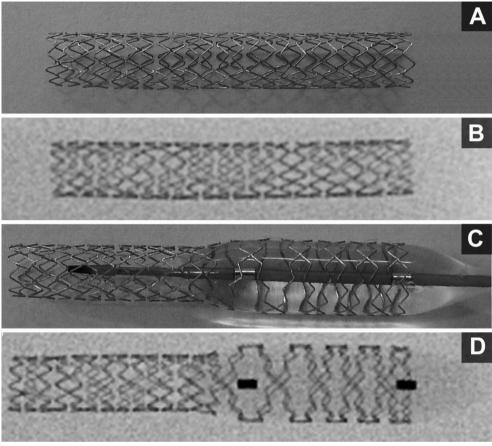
DES postdilatation (example of Endeavor Resolute stent): A) Photograph of DES after expansion at 14 atm; B) high resolution radiographic image of A; C) photograph of partial proximal postdilatation with 5 mm non-compliant balloon at 18 atm; D) high resolution radiographic image of C (please note the large size of stent cells at the position of the distal balloon marker).
